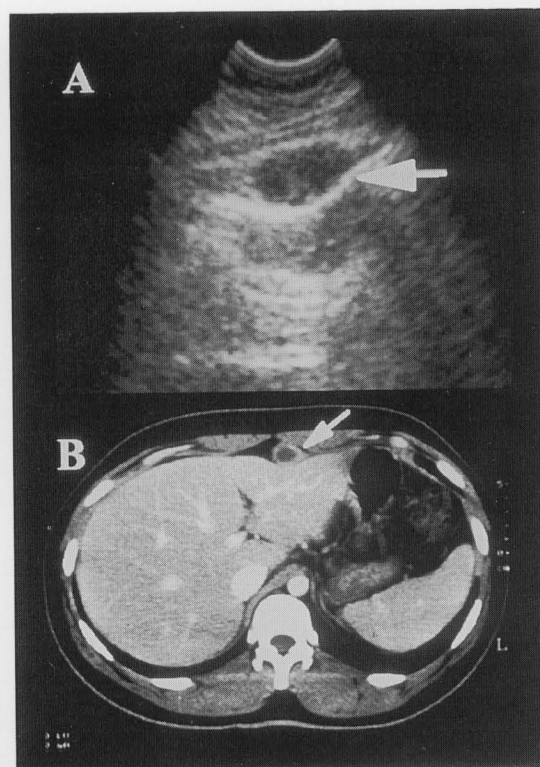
A: Ultrasonography revealed a hypoechoic tumor measuring 20×20 mm corresponding to the accumulation of radioactivity detected on Ga-67 scintigraphy. B: Enhanced computed tomography imaging of the abdomen revealed a tumor with ring enhancement.
